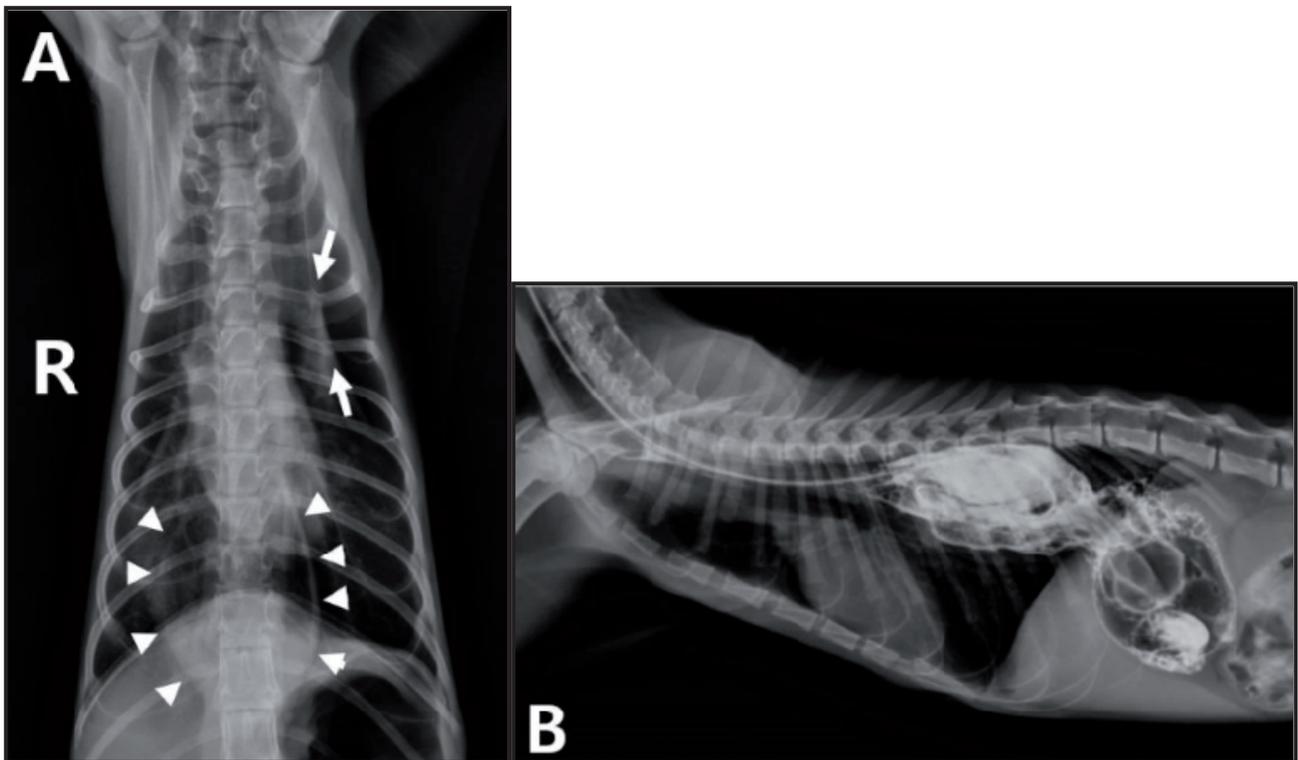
Throacic radiography. A- On a ventrodorsal radiographic image, 4th and 5th rib fractures (arrow) with left cranial lung lobe collapse were identified. Megaesophagus, along with gaseous filtration (arrowhead), were also identified. B- On a right lateral radiographic image of the positive-contrast esophagram, a hiatal hernia and megaesophagus were identified.
